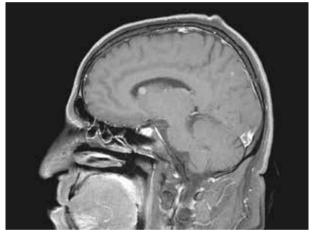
Brain magnetic resonance imaging with tumoral activity in the left parietal central nervous system and left thalamus.
